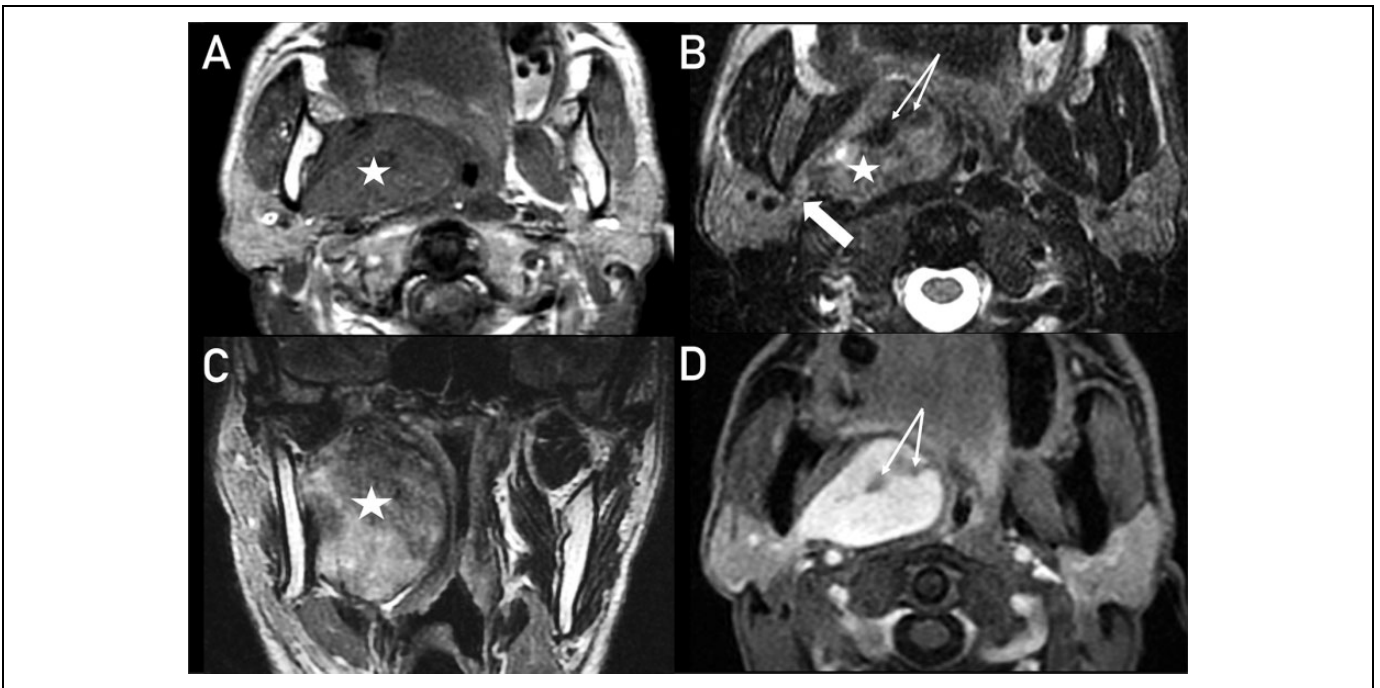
Magnetic resonance imaging (MRI), T1-weighted image (WI) axial planes (A), T2-WI axial (B) and coronal (C) planes, and post-gadolinium T1-WI axial plane (D). The lesion (star) was isointense to muscle on T1-WI, showing a variable signal on T2-WI with predominant zones of high signal. After gadolinium injection, a vivid enhancement was demonstrable. Note some areas of constant hypointensity (arrows). The continuity between the mass and the deep lobe of the parotid gland was evident in (B) (white arrow).
